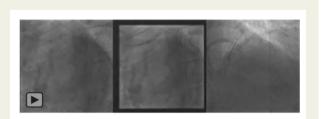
(A) Final angiogram. (B) Intravascular ultrasound left circumflex–left main, left anterior descending ostium seen with (white star) clearing of struts. (C) Intravascular ultrasound of Proximal Cx showing good stent expansion. (D) Intravascular ultrasound left anterior descending–left main, left circumflex ostium at the distal left main seen with clearing of struts (red star). (E) Intravascular ultrasound of mid showing good stent expansion.
